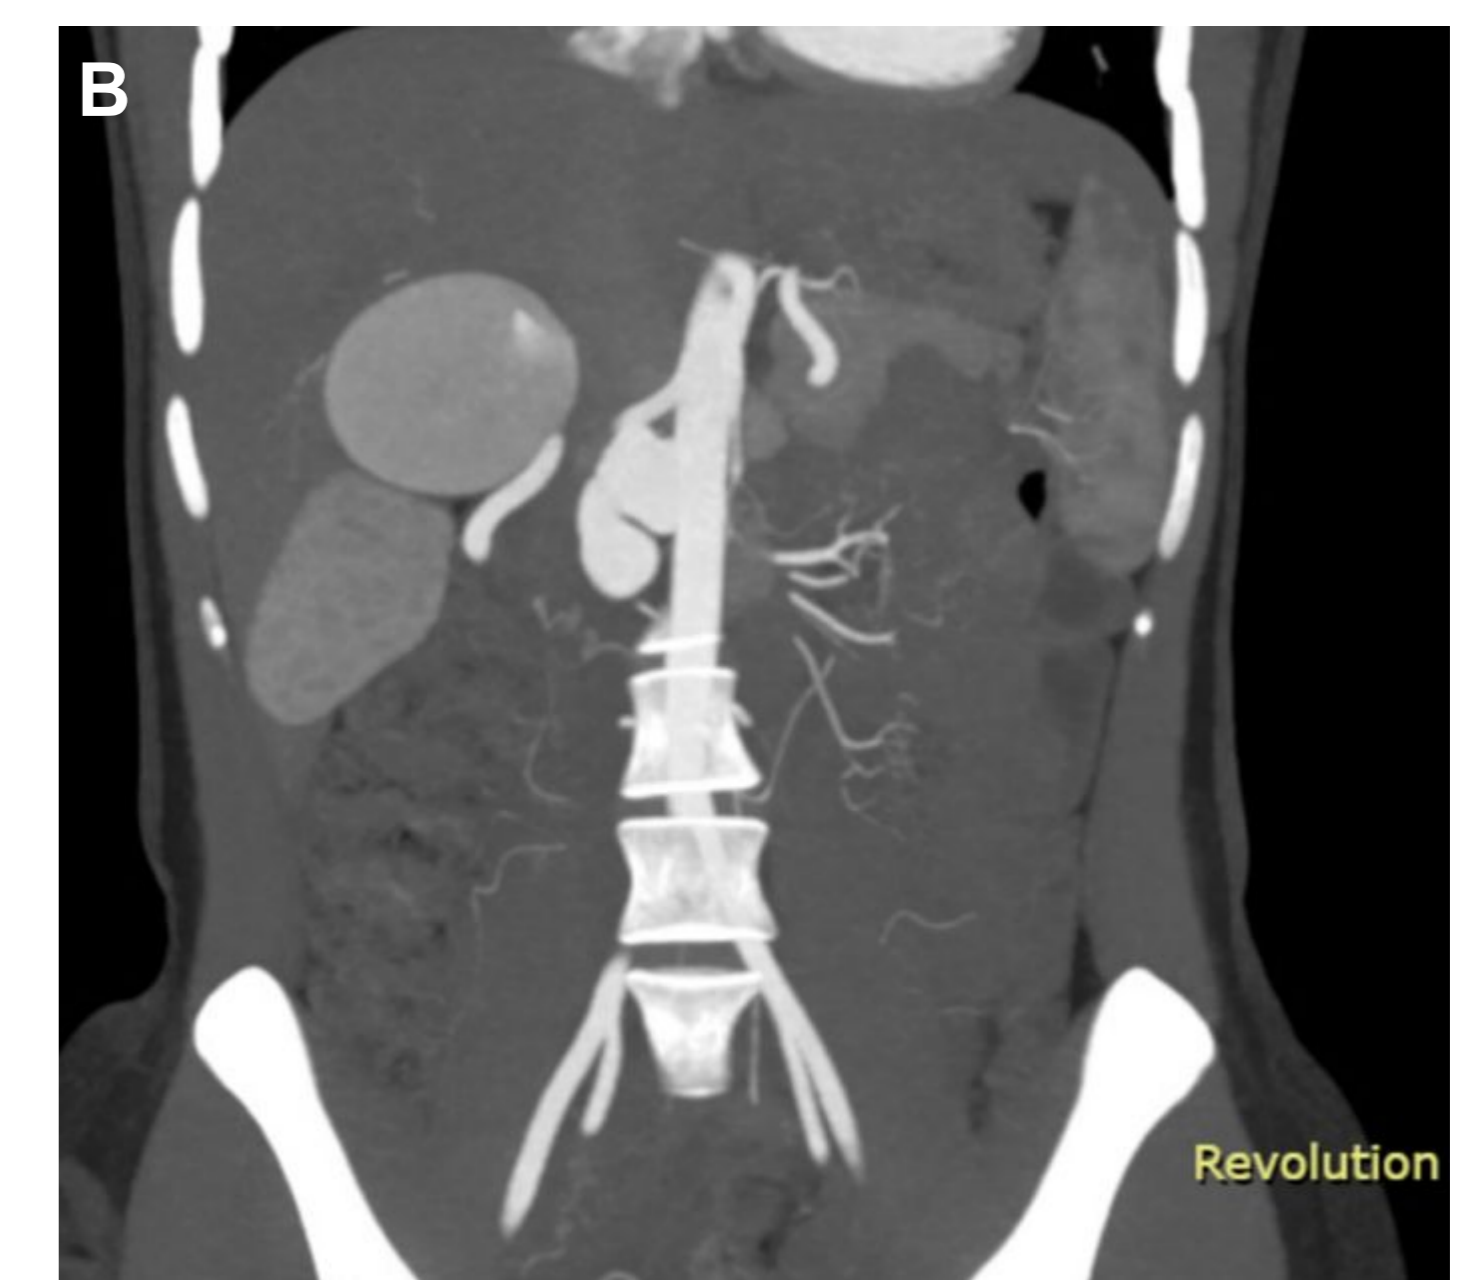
CTA Abdomen with contrast
